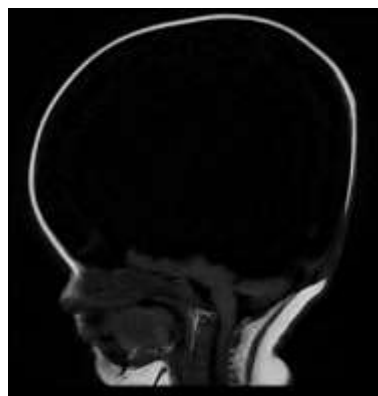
T1W MRI sagittal section shows supra tentorial cerebral parenchyma replaced by CSF density. However, posterior fossa and brain stem structures appear normal.
